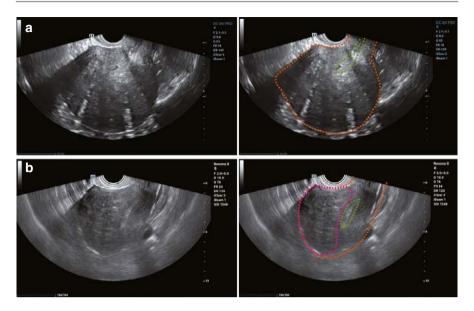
(a) Diffuse adenomyosis: The uterus is spherically enlarged, with the posterior wall being most prominent. The endometrium is poorly visualized, and multiple small fluid areas are identified within the affected myometrium. The uterus is circled in orange; the endometrium is circled in green. (b) This ultrasound image shows adenomyosis confined to the anterior wall of the uterus, with posterior displacement of the endometrium and multiple small fluid areas within the affected myometrium. The uterus is outlined in orange; the endometrium is circled in green; the adenomyosis is circled in pink
